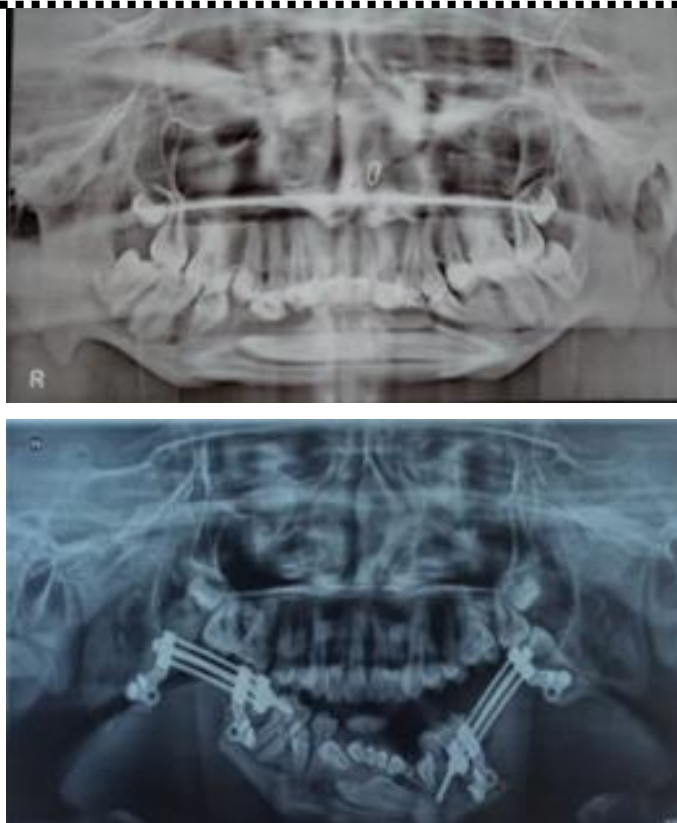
Pre- and post- operative radiographs depicting distraction of 25 mm.
